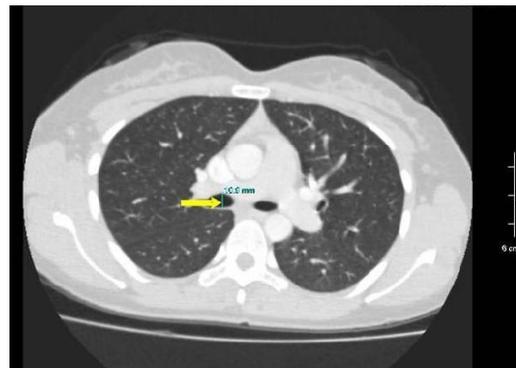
Right main bronchus AP diameter measurement on axial CT image
